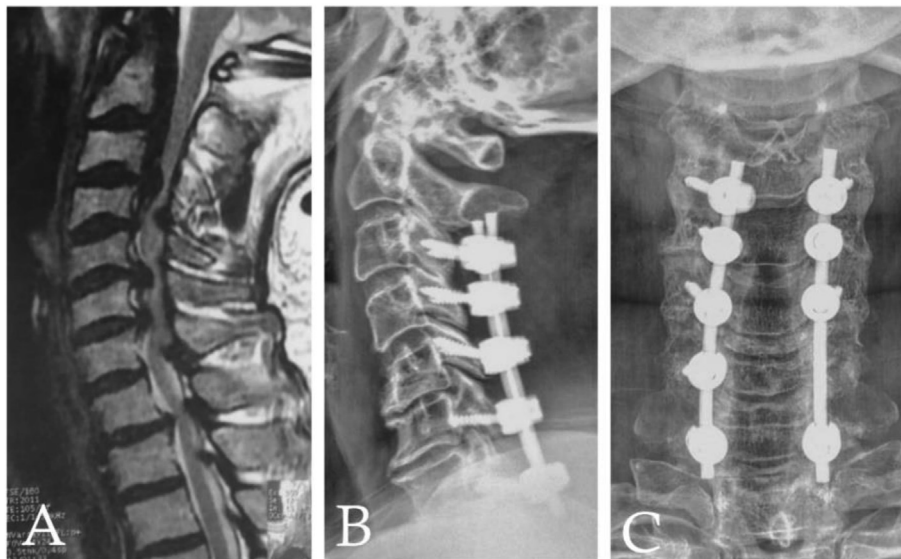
(A) Preoperative MRI of a 66-year-old male patient presented with degenerative cervical myelopathy and operated for posterior cervical laminectomy and lateral mass fixation using free-hand technique; (B) postoperative plain X-ray showing facet violation at the level of C6; (C) AP view of X-ray showing the skipped level of fixation at the left lateral mass of C6, which has been fractured intraoperatively.
